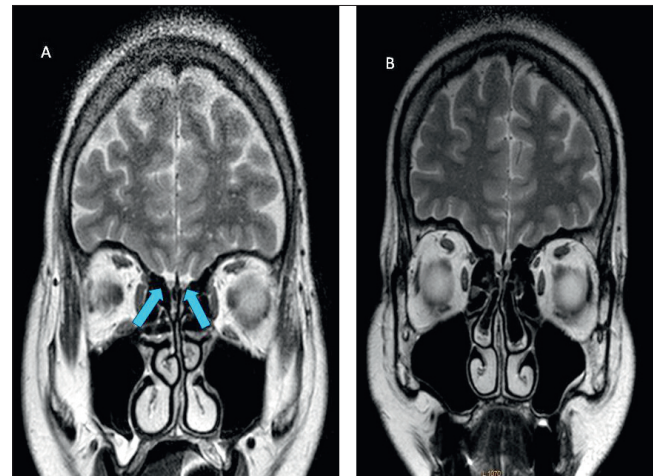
T2-weighted coronal image with decreased olfactory bulb volume (arrows)(A) and control image (B).
